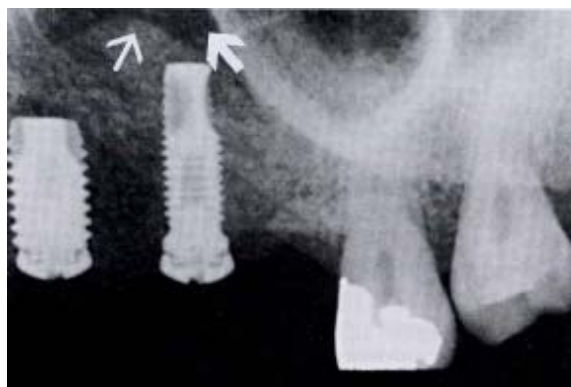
Immediate post-operative radiograph of the implants and the grafted sinus. Note radiographic texture of the grafted sinus with appearance of radio-opacity of the lateral bone window of the maxillary sinus ( $\leftarrow$ ), and radiolucent spots of the grafted materials ( $\leftarrow$ ).
